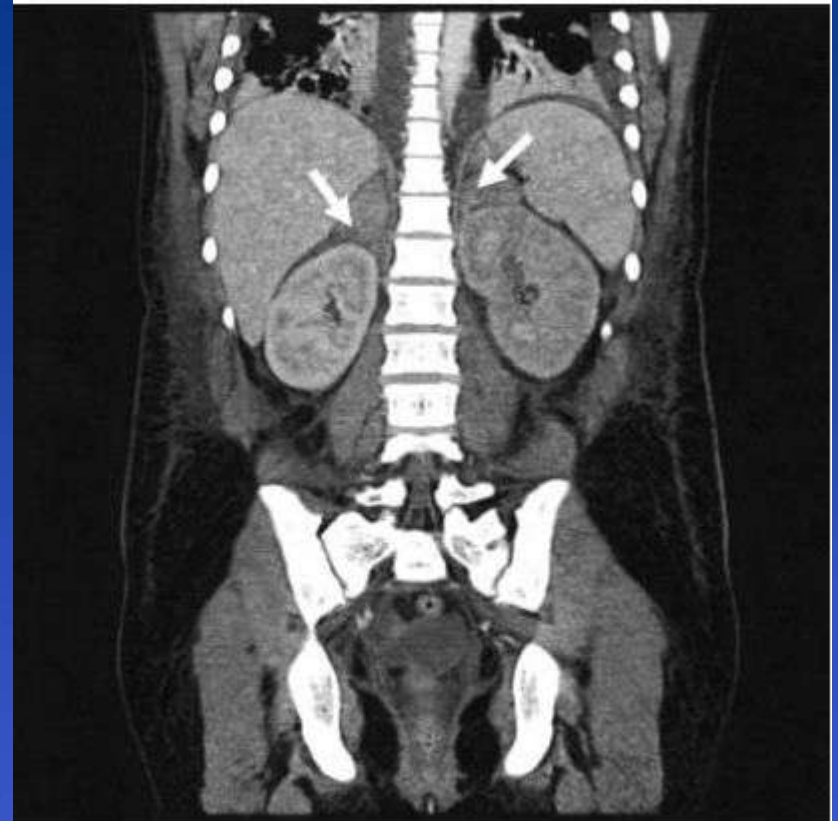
Computed tomography of the abdomen showing bilateral adrenal hemorrhages (arrows).
